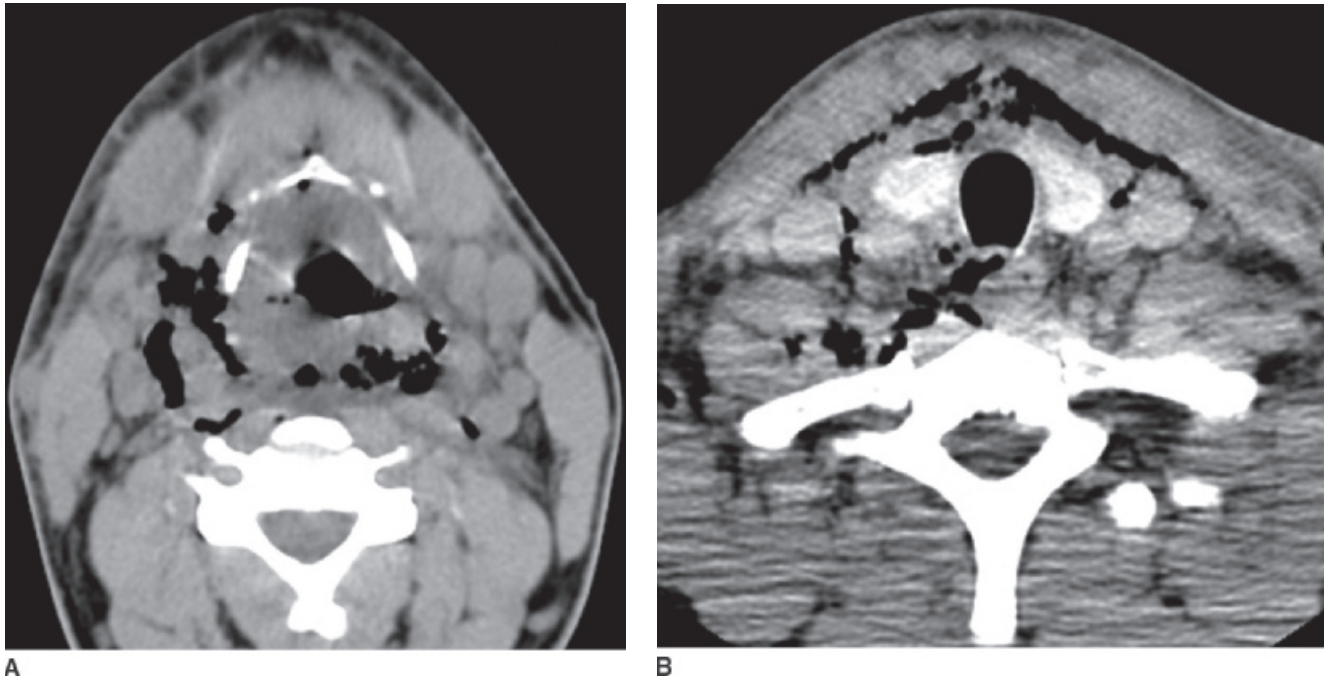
Necrotizing fasciitis. Axial unenhanced CT images at the level of the hyoid bone (A) and thyroid gland (B) show extensive gas formation throughout the deep fascial compartments of the neck. There is also extensive infiltration of the fat planes, which distinguishes this case of necrotizing fasciitis from perforation of the upper aerodigestive tract.
